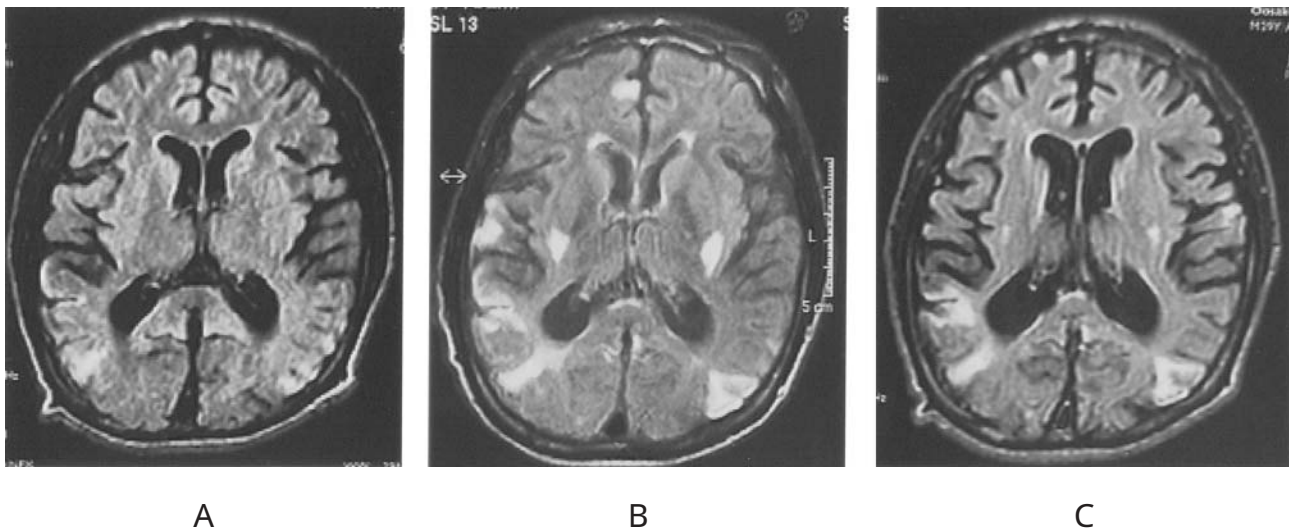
MR FLAIR image shows a mixture of remissive and recurrent foci. A) January 2001, B) February 2002, C) June 2003.
